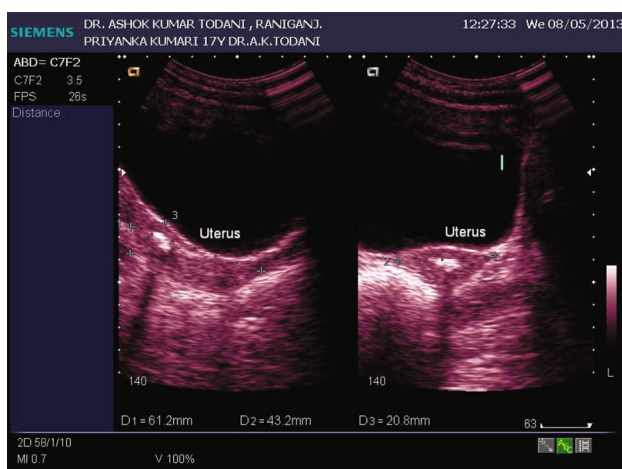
Transabdominal pelvic ultrasound (uterus)
